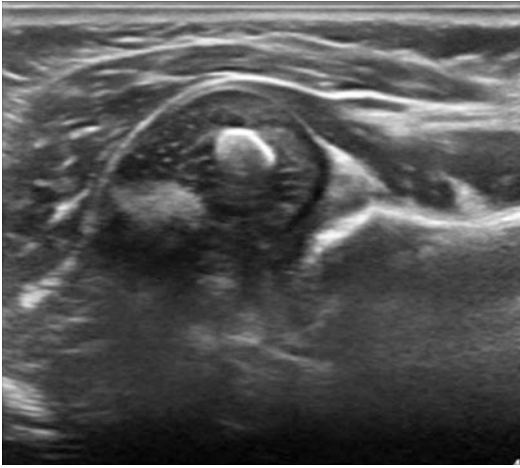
Ultrasound image of an infant with posterior glenohumeral dysplasia and humeral head positioned posteriorly within the glenoid fossa
